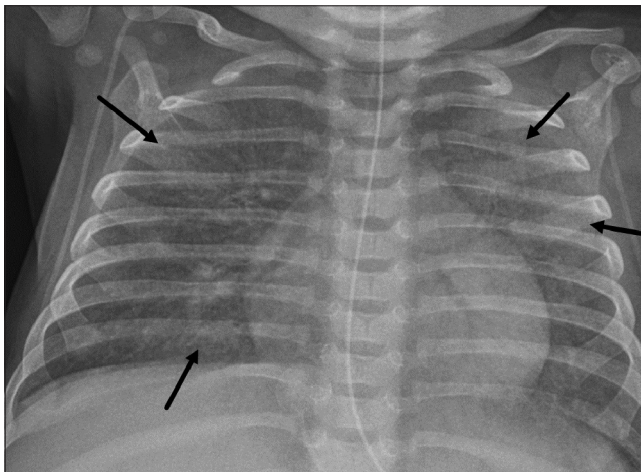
Chest radiograph of a 4-month-old HIV-positive male infant with pneumocystis pneumonia shows bilateral hazy airspace opacities (black arrows)
